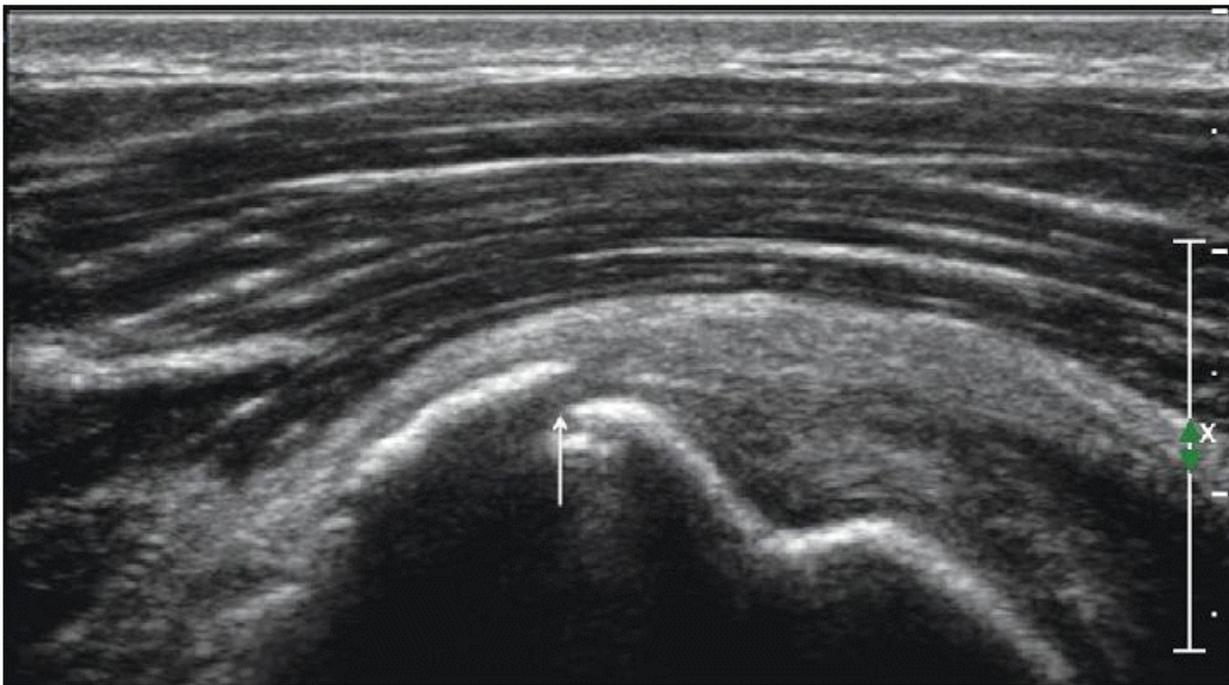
Sagittal oblique scan of shoulder showing a radiographically occult greater tuberosity fracture (arrow). The fracture fragment is elevated by <1 mm.
